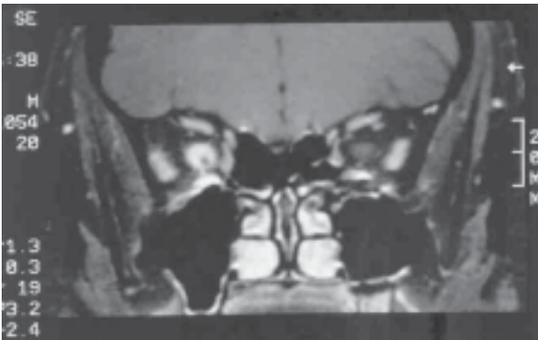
Coronal T1-weighted MRI with gadolinium enhancement and fat suppression shows enhancing right optic nerve sheath meningioma surrounding the optic nerve. The nerve itself appears as a small hypodense central area. Note irregular appearance of the borders of the region of enhancement.
